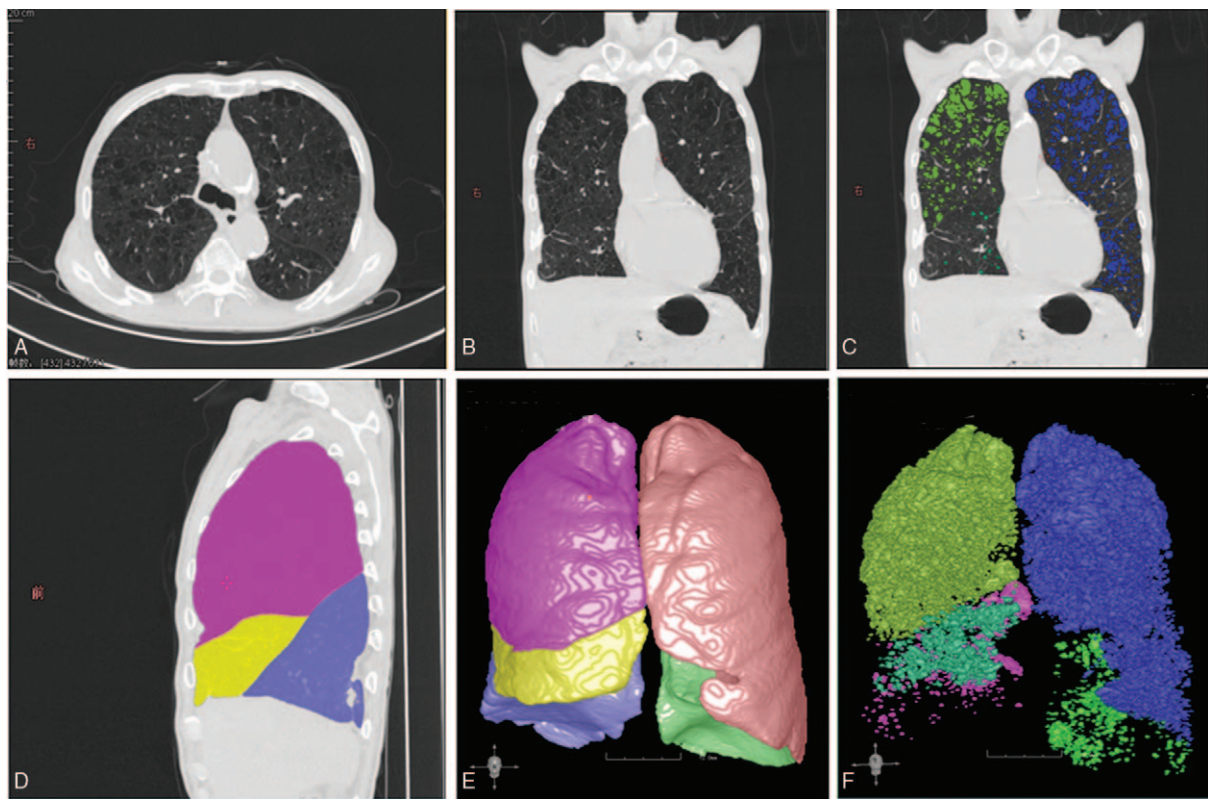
A 3-D surface model of the extent and distribution of emphysema. (A) a transverse view of the original CT image; (B) a coronal view of the original CT image; (C) LAA area is highlighted; (D) automatic segmentation of the pulmonary lobes from chest CT scans based on fissures; (E) 3-D surface model of the pulmonary lobes segmentation; (F) 3-D surface model of the distribution of emphysema in the whole lung and individual lobe (the LAA in individual lobe showing in different color). CT=computed tomography, LAA=density attenuation area.
